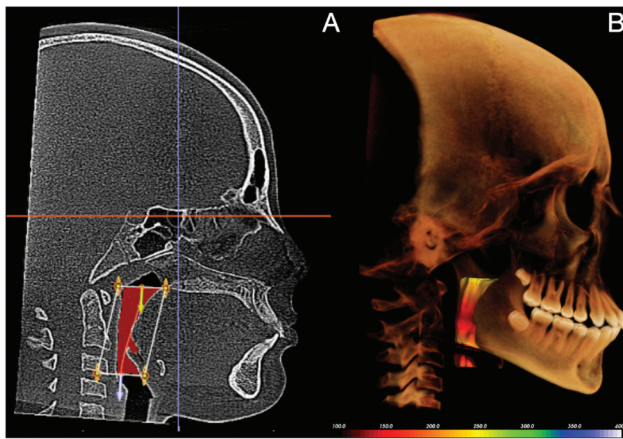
CBCT craniofacial scan. A) lateral sagittal cross-section corresponding to exported measurements; B) 3D volumetric rendering with color mapping, highlighting the anatomical region of interest and density variations.
